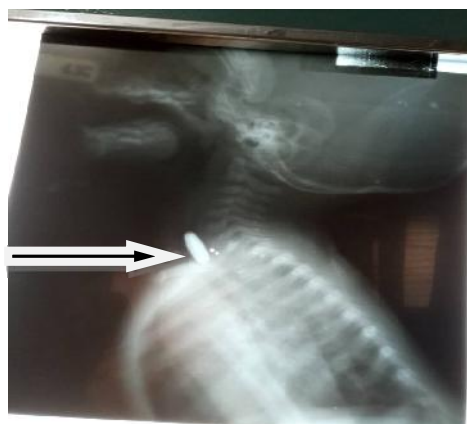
A Plain radiograph of the lateral soft tissue of the neck.
